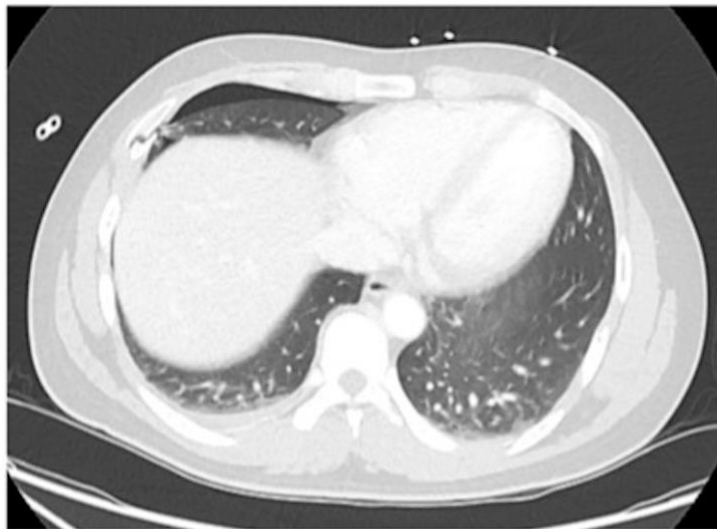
CT demonstrates right pneumothorax, displaced right sixth rib fracture with right middle lobe trapped within rib fracture.
